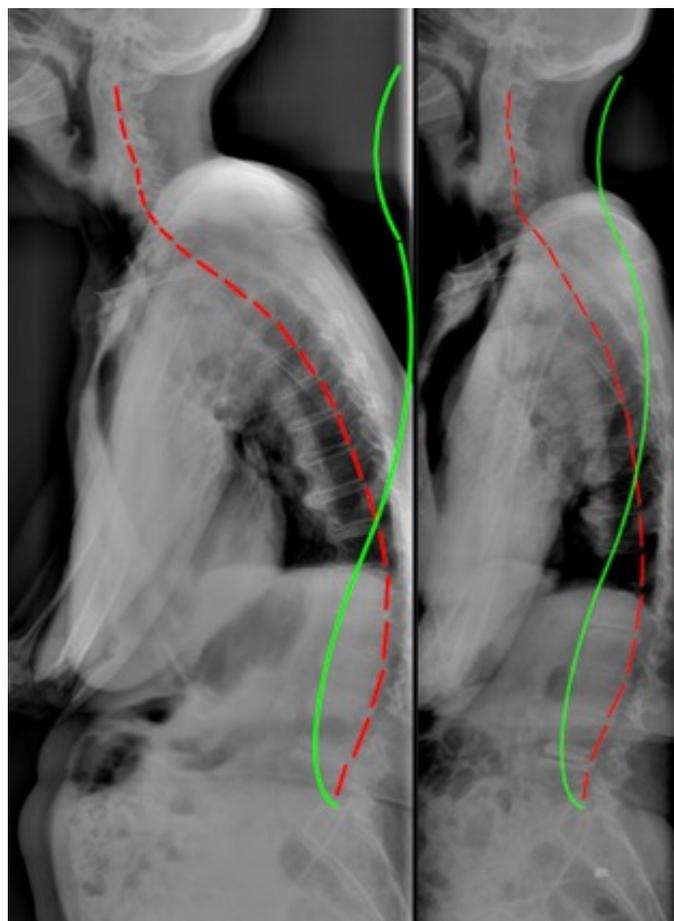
Lateral full spine radiographs. Left: Initial radiograph demonstrating excessive anterior thoracic posture subluxation; Right: Follow-up after 24 treatments after 4 months shows significant improvement in postural parameters. See text for details. Red line highlights patient, green line indicates ideal alignment.
